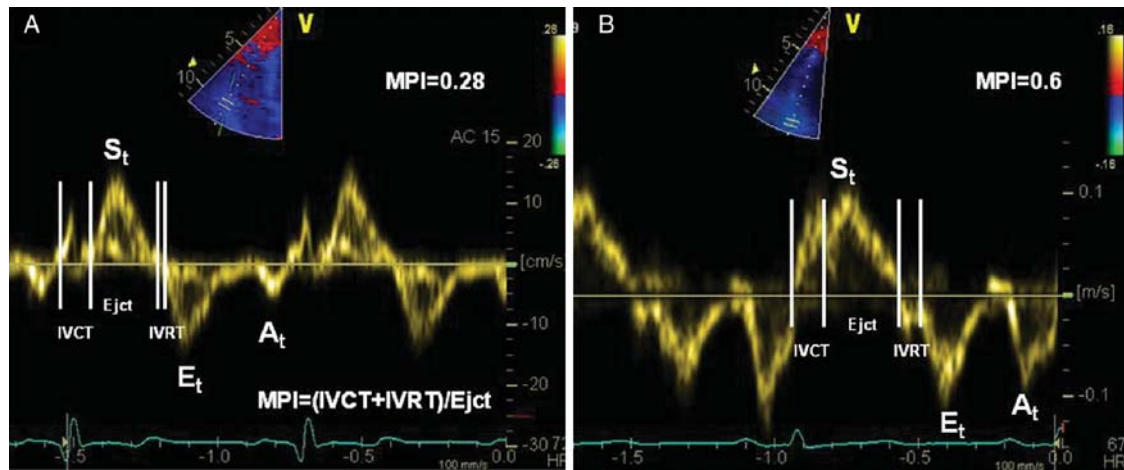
Pulsed-wave Doppler at the tricuspid level of the right ventricular free wall in a normal individual (A) and in a patient with pulmonary hypertension (B). MPI, myocardial performance index; IVRT, isovolumic relaxation time; IVCT, isovolumic contraction time; Eject, ejection time; S_t , peak systolic velocity at the tricuspid valve; E_t , peak early filling velocity at the tricuspid ring; A_t , peak late filling (atrial) velocity at the tricuspid ring.
